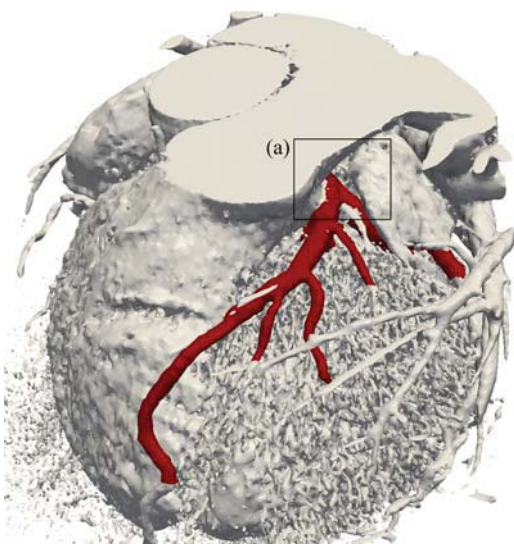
Volumetric model obtained from the original multislice computed tomography (MSCT) data. The left coronary artery is marked in red. The modeled segment of plaque free coronary artery bifurcation is marked with (a).
